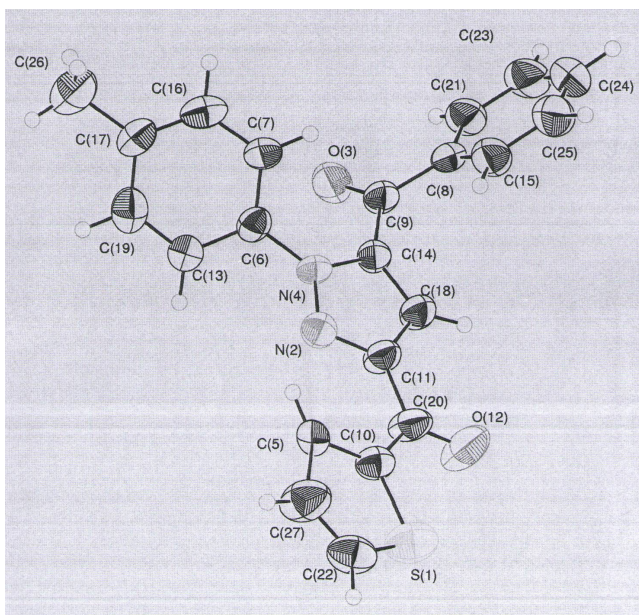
Thermal ellipsoid plots of the X-ray structure of 7b (50 % probability).
